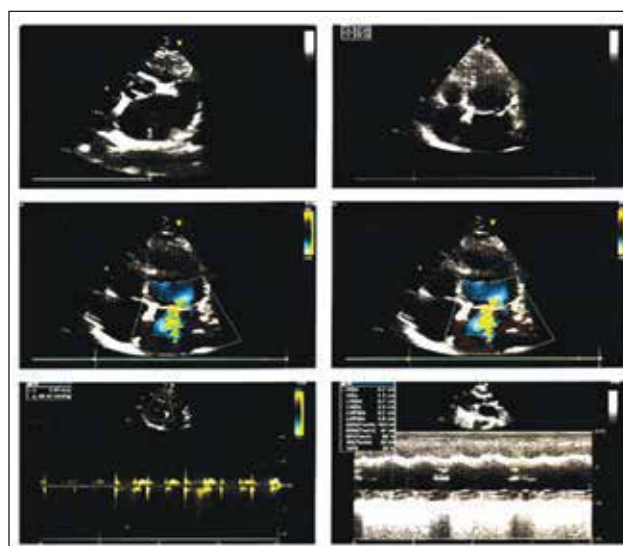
Echocardiographic findings after restoring near normal thyroid function showing posterior mitral leaflet (PML) prolapse, moderate mitral regurgitation (MR), pulmonary artery systolic pressure (PASP) 48 mmHg, and left ventricular ejection fraction (LVEF) 60%.
